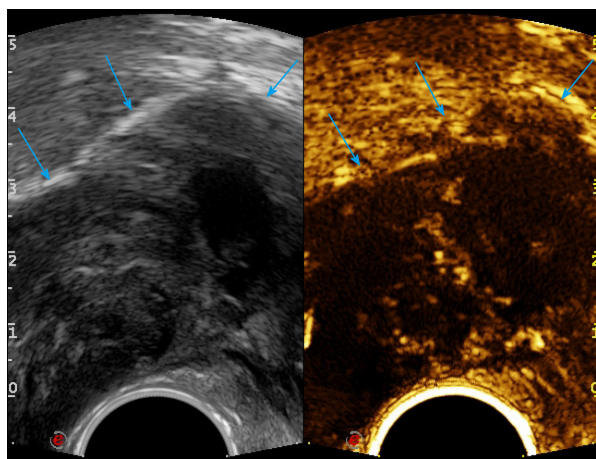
Endorectal ultrasound performed with the convex probe of TRT33. Liquefaction necrosis and cellular appearance were found inside the tumor in transverse sections, and the solid part of the tumor was either hypo- or iso-enhancing. Arrow: Rectal stromal tumor.
